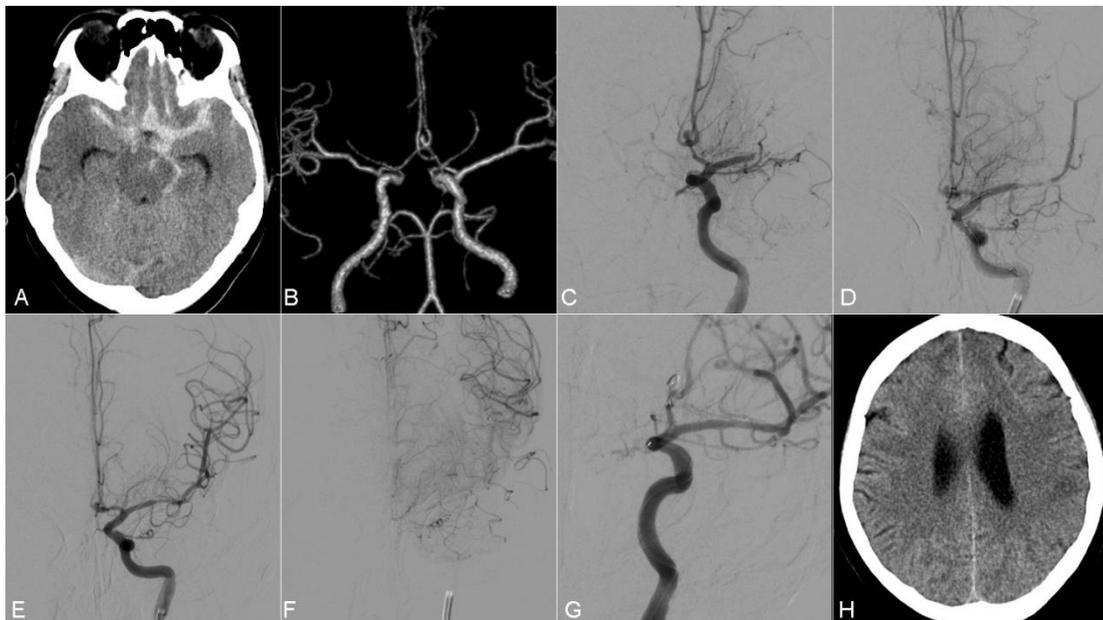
Images of case3. A: The emergency head CT scanning showed subarachnoid hemorrhage in the suprasellar cistern with a modified Fisher score of 3. B: The CT angiography displayed a anterior communicating aneurysm about 3mm*2mm in size. C and D: Thromboembolic occlusion developed in the M1 segment of the left MCA before coiling of the aneurysm, and was recanalized by mechanical thrombectomy. E: The angiography revealed recanalization and local vasospasm of the M1 segment of left MCA. F: Delayed development of the distal arteries of the MCA suggested distal migration of the thrombus. G: The aneurysm was successfully treated with simple coiling. H: Local cerebral infarction was found in the left parietal lobe on the postoperative head CT scan.
